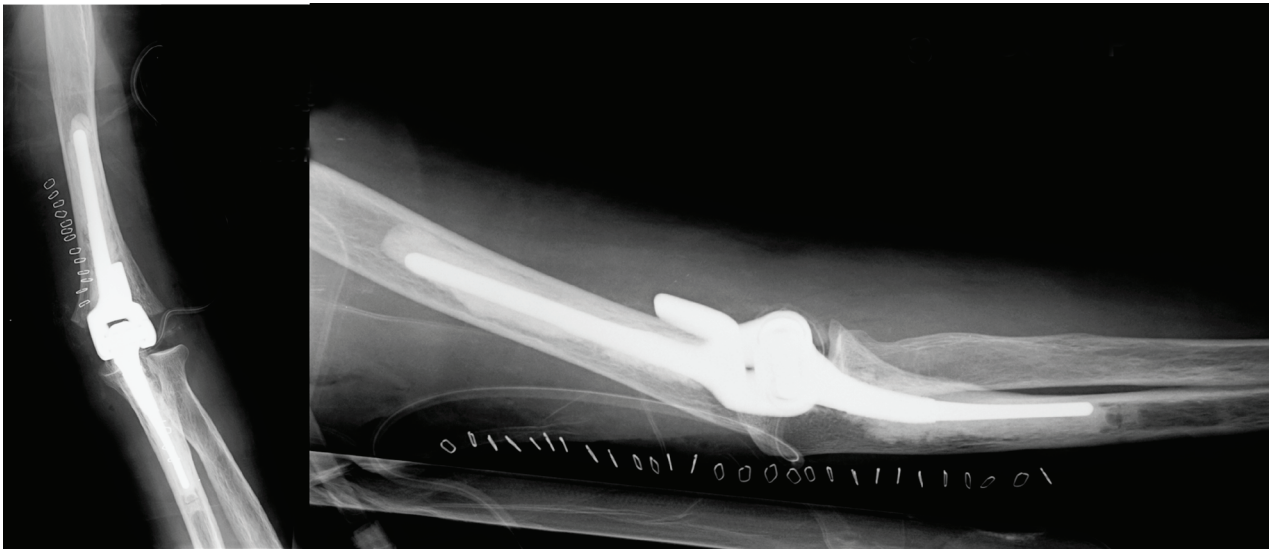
Postoperative X-rays of Conrad-Morrey implant; grade 2 PE-Morrey criteria.
